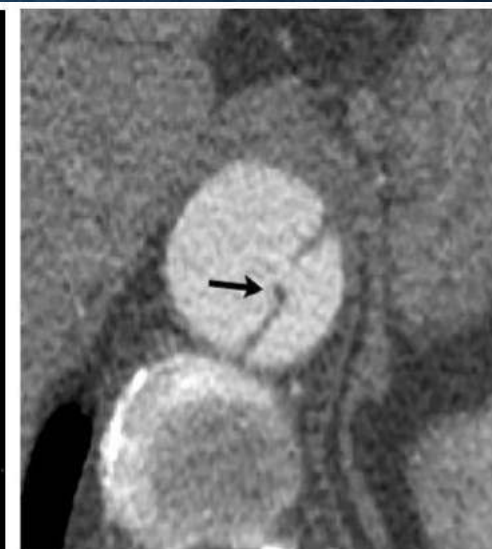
57 year-old male with a chronic, 100 day-old type B aortic dissection. CT scan near the level of the diaphragm shows a dissection flap tear edge (arrow) that is thickened and curled into the FL
